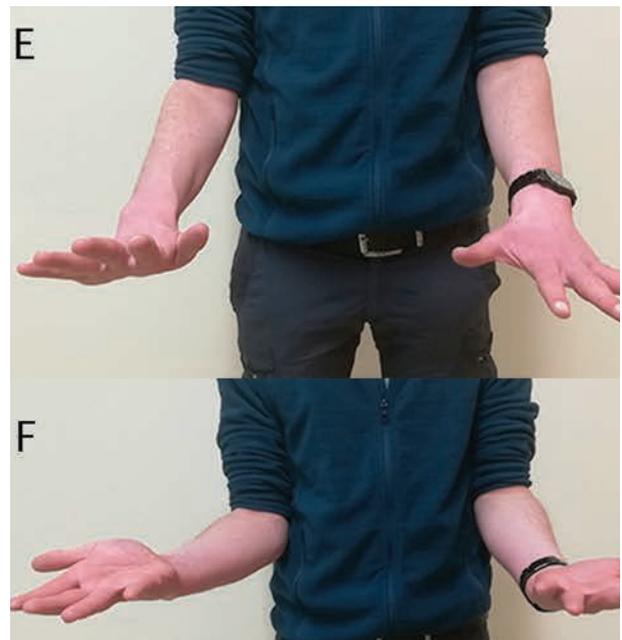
Pre-operative (A) and post-operative X-rays (B). Fracture's healing 7 months after surgery (C and D). No limitation of strength and of ROM at clinical evaluation (E and F)
